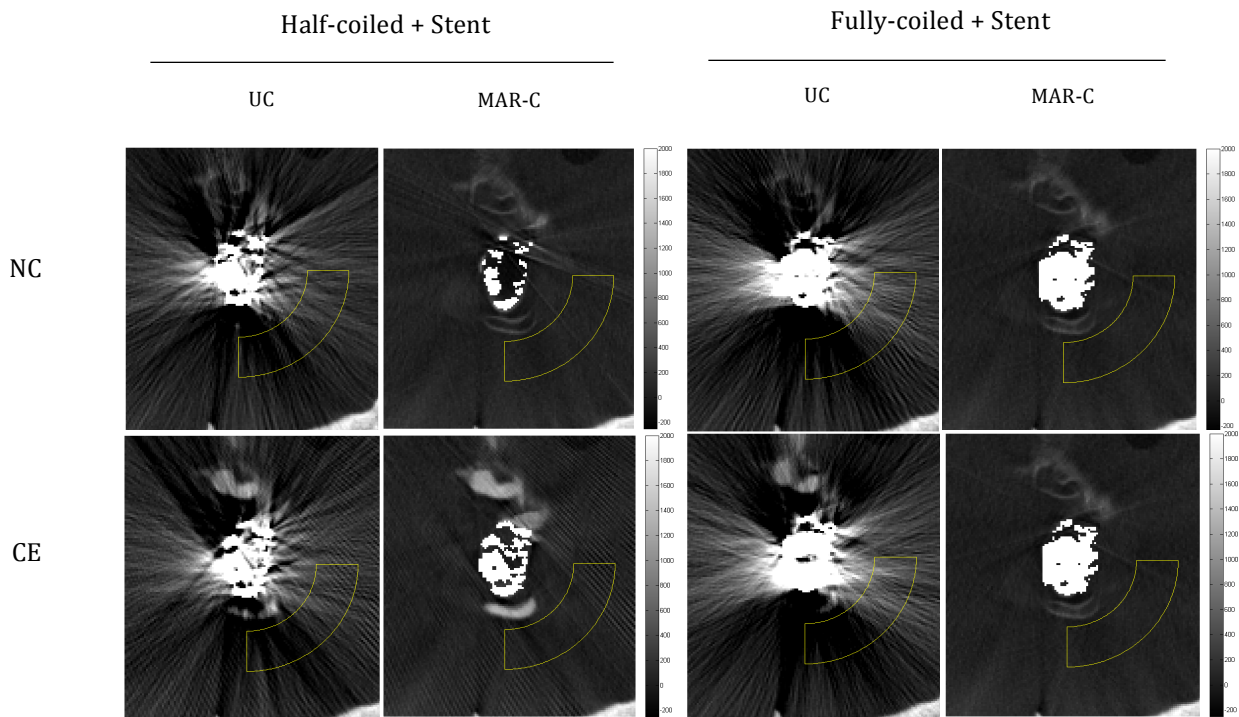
Uncorrected (UC) and MAR corrected (MAR-C) CT images of a half-coiled and fully-coiled aneurysm both with a stent and non-enhanced (NC) and contrast-enhanced (CE) solutions. Background ROIs are shown in yellow.
